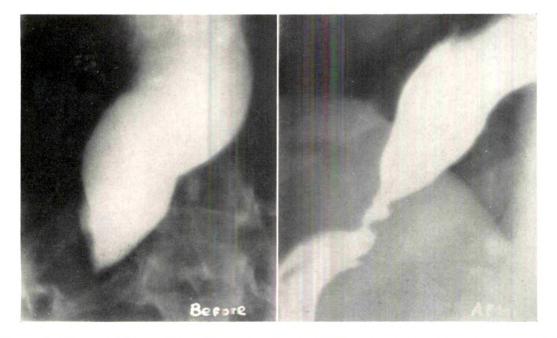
Cardiospasm. Relief of obstruction by nitroglycerine. P. R., male, aged twenty-four. Acute onset of esophageal obstruction about three years ago. Esophagoscop howed no organic lesion. Passage of bougies resulted in temporary relief. Roentgen studies (before) showed marked dilatation of the esophagus with stenosis at the cardia. After the administration of 1/10c grain of nitroglycerine, the stenosis disappeared and the esophageal contents passed rapidly into the stomach.
